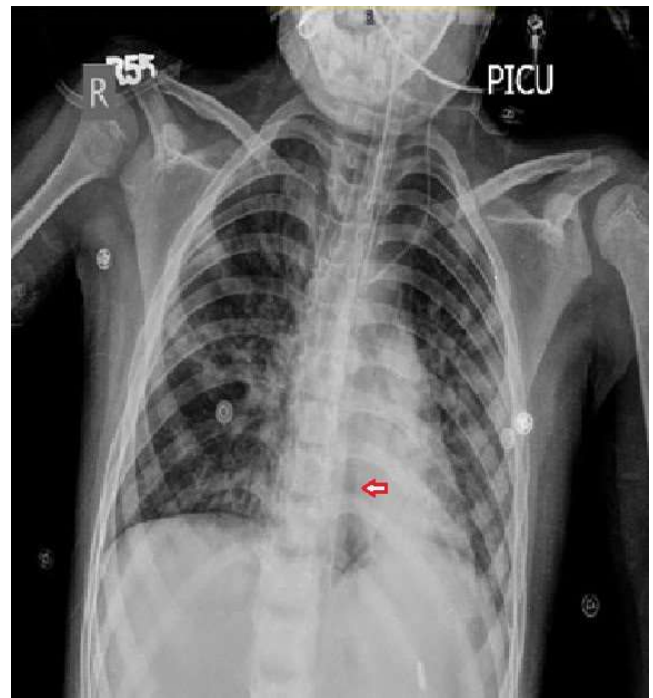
Chest X-ray showing the presence of Pneumomediastinum (red arrow)
